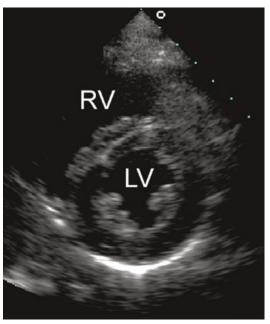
Parasternal short-axis of the left ventricle at the level of the two papillary muscles
